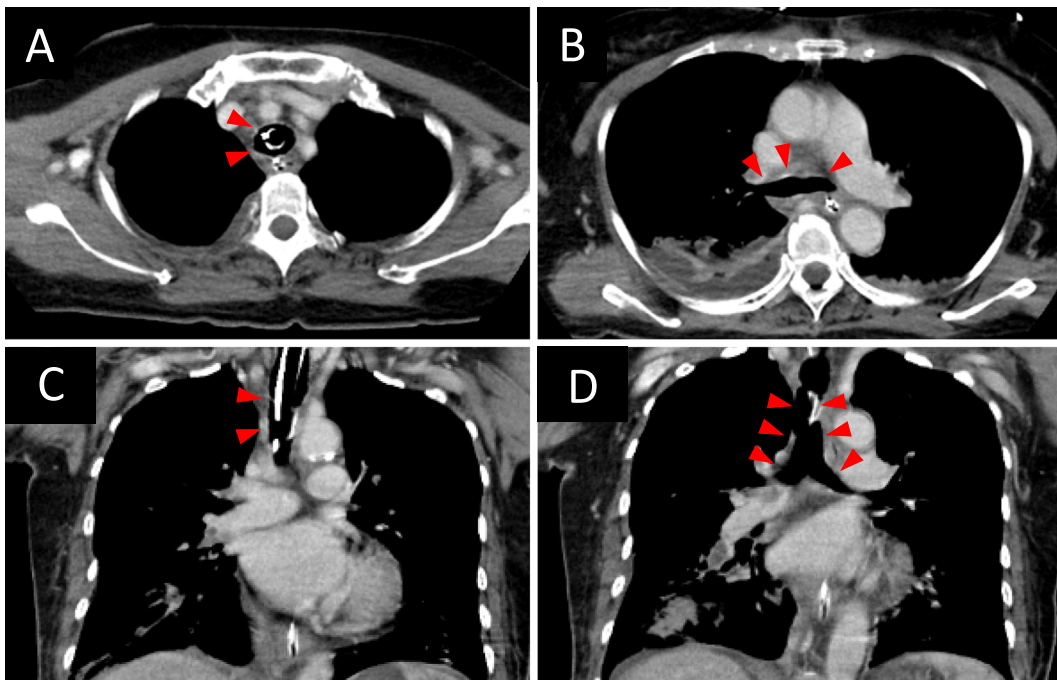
Contrast-enhanced CT images. Axial (A, B) and coronal (C, D) images of the chest after removal of a blood clot. After successful attempts to remove the blood clot, patency was achieved in the trachea and the bilateral mainstem bronchi (red arrows). CT: computed tomography
